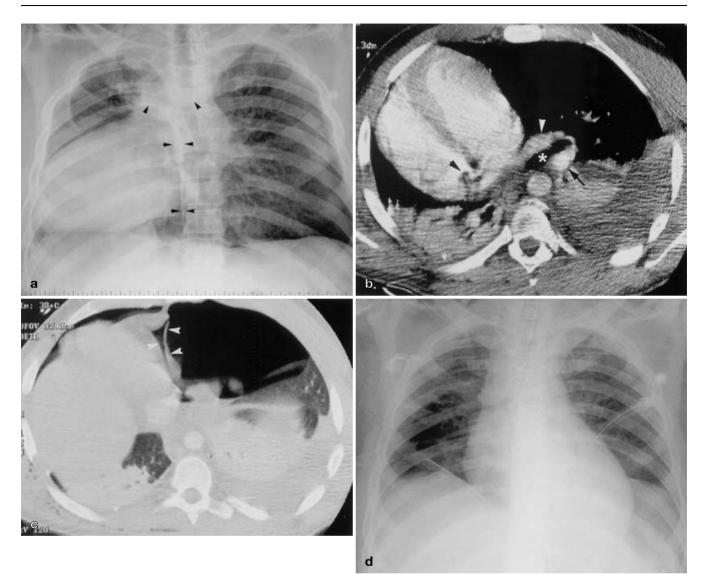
A 36-year-old man who had a severe ski accident. a Antero-posterior chest X-ray. Right-sided heart without patent abnormality of cardiac contour but the left border is located in the right hemithorax. The border of the descending aorta cannot be seen. A long medial vertical line (arrowheads) is seen. The upper part is thick and corresponds to the anterior mediastinal line and the lower part is thin and corresponds to the left pleuropericardium. There are no signs of pneumomediastinium or pleuropericardium. b Axial enhanced CT scan (3 mm thick). Window level: 58 HU; width 394 HU. The heart is dislocated in the right hemithorax, and right cardiac chambers are located posteriorly to the left ones. A spur is seen on the posterior wall of the right atria (black arrowhead), related to a bending of this wall. The left bronchus (asterisk), the left superior pulmonary vein (white arrowhead) and the left pulmonary artery (black arrow) are located anterior to the descending aorta. The right inferior lobe is collapsed and a left pleural effusion is visible. c Axial CT scan (3 mm thick) at the level of the right diaphragm and inferior vena cava. Window level: -400 HU; width 1600 HU. The pericardial sac is visible (white arrowheads) as a triangular cavity underlined by the bilateral pneumothorax. d Postoperative chest X-ray control. Normal cardiac shadow
